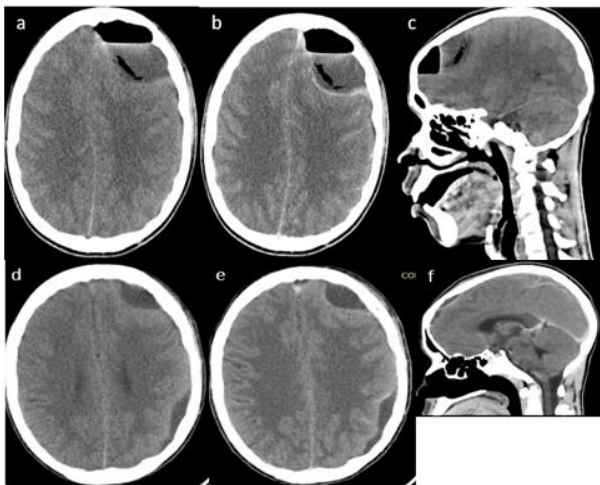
(pre-operative image-a to c)- Cranial CT of a 17-year old with moderate head injury, early focal right tonic-clonic
